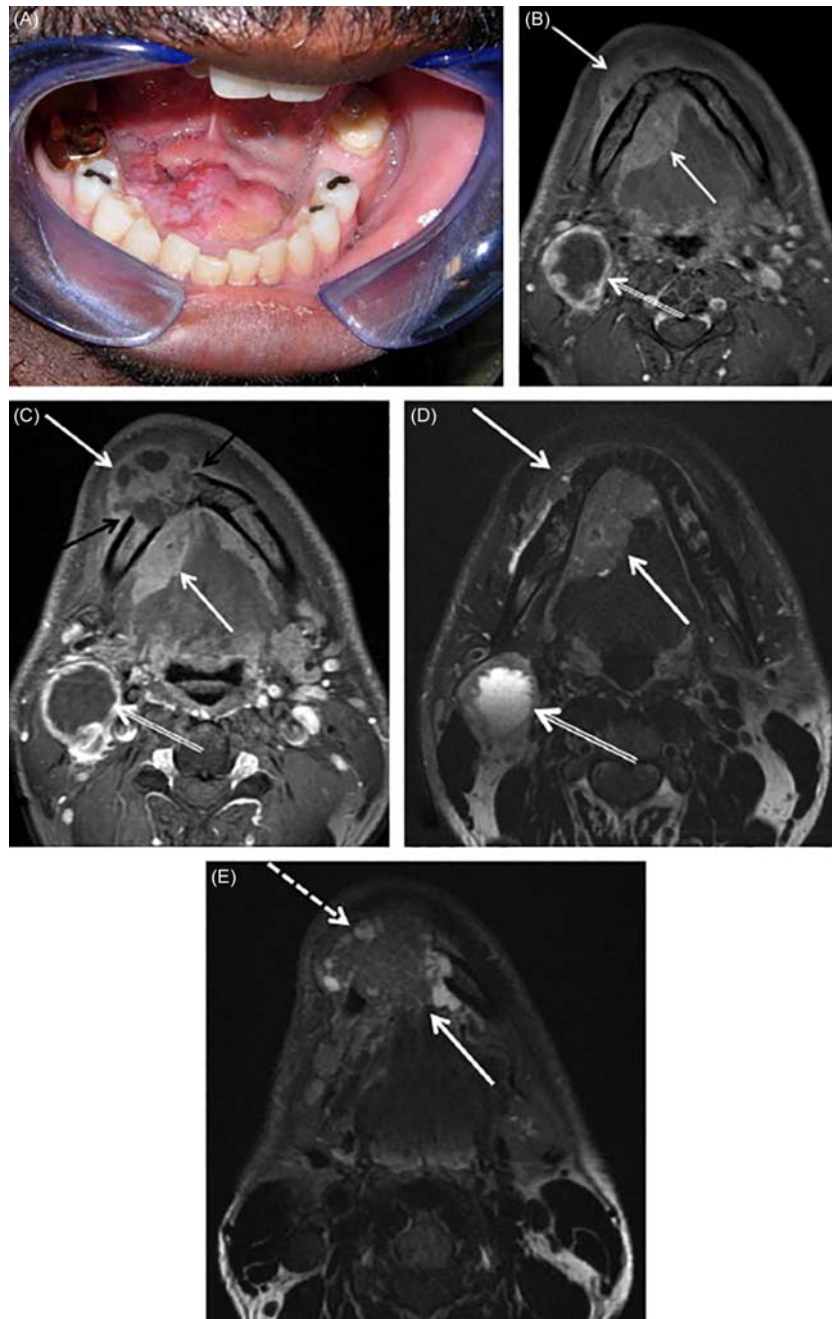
T4a floor of mouth squamous cell carcinoma with bone invasion and necrotic right level II nodal metastasis. (A) Photograph shows a large exophytic and ulcerated mass in the right floor of mouth extending across the midline. (B, C) Axial postcontrast fat-saturated T1-weighted images from superior to inferior show a large heterogeneously enhancing mass with areas of necrosis in the right floor of mouth (*solid white arrows*) extending across the midline anteriorly. Gross tumor invasion of the mandible with erosion through the outer cortex is seen (*solid black arrows* in C). No evidence was seen on imaging of perineural invasion in the inferior alveolar canal. A large necrotic right level II node is seen posteriorly (*double-lined white arrows*). (D, E) T2-weighted fat-saturated images from superior to inferior similarly show a mass in the floor of mouth (*solid arrows*) extending across the midline, with anterior extension through the mandible into the submental region (*dashed white arrow* in E). Note the low T2 signal intensity of most of the mass, indicating hypercellularity. The necrotic right level II node (*double lined white arrow* in D) is also seen. From Hagiwara, M., Nusbaum, A., Schmidt, B. L. (2012). MR assessment of oral cavity carcinomas. *Magnetic Resonance Imaging Clinics of North America* 20(3), 473–494.
